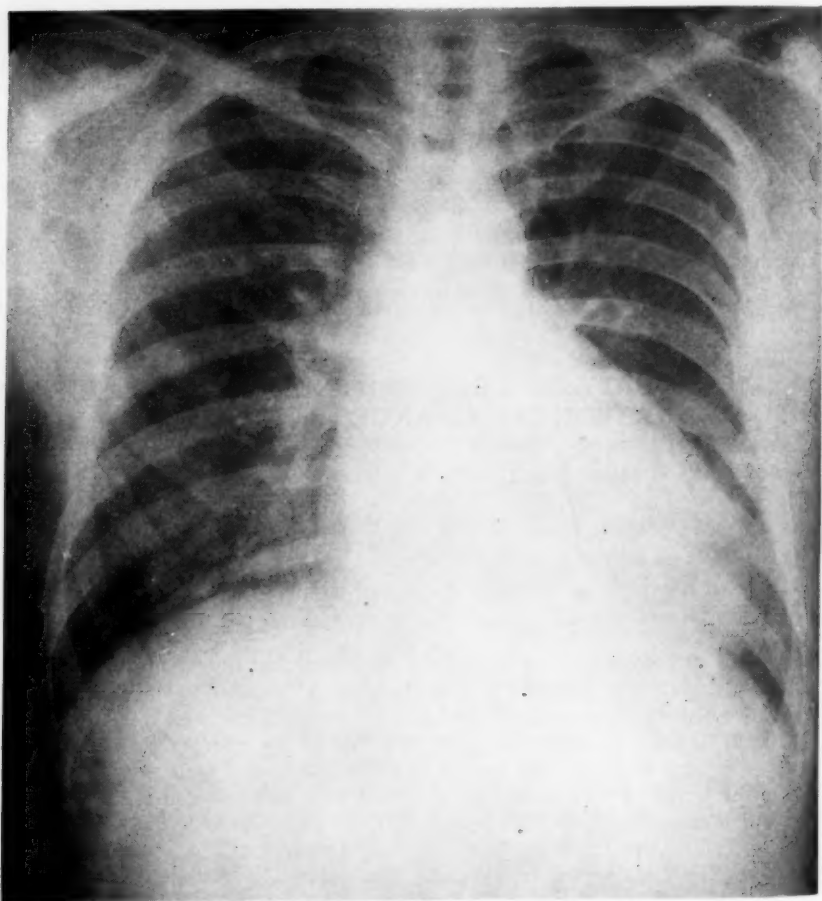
Roentgenological appearance of the chest at the time of the first examination of the patient, 2-13-33.
